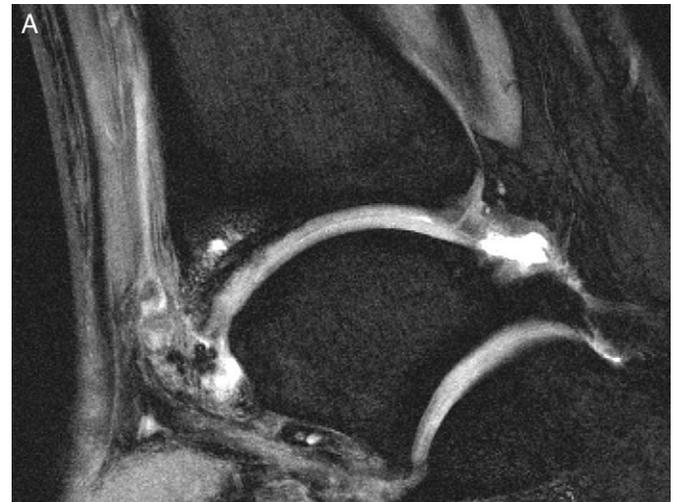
Follow-up at 36 months. Sagittal magnetic resonance image demonstrates intact cartilage covering of the anterior defect (A). Quantitative analysis of the repair zone (dGEMRIC) shows nearly normal glycosaminoglycan content of the repair tissue compared with healthy surrounding cartilage (B, color scale indicates T1 relaxation times).
